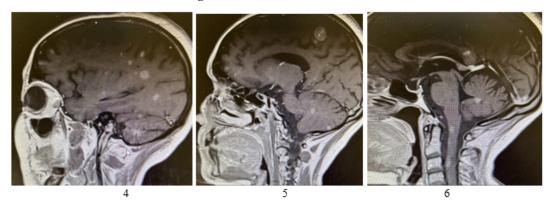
MRI brain November 2020.
